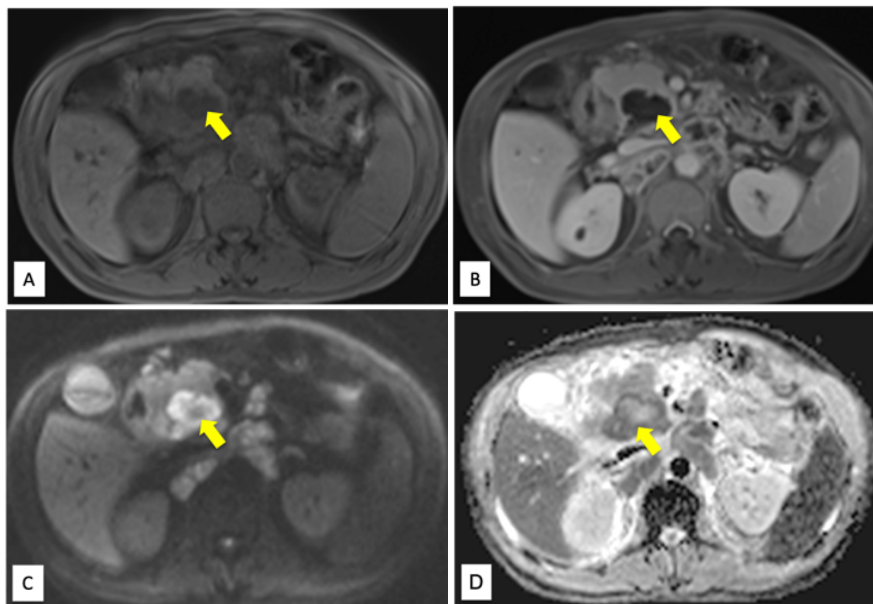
MRCP axial views. (A) Pre-contrast, (B) Post-contrast. The lesion shows peripheral enhancement after contrast administration. It appears bright on DWI (C) and dark on ADC (D) images reflective of restricted diffusion.
